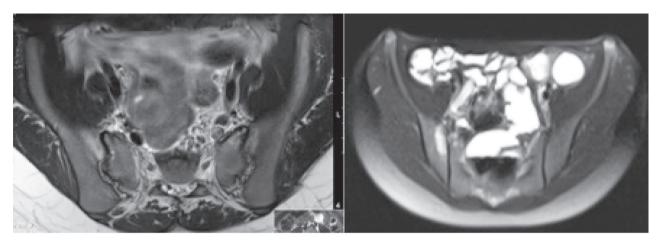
Contrast-enhanced T2-weighted magnetic resonance enterography image showing high signal on the sacral and iliac sides of right sacroiliac joint, compatible with a "positive" MRI.
